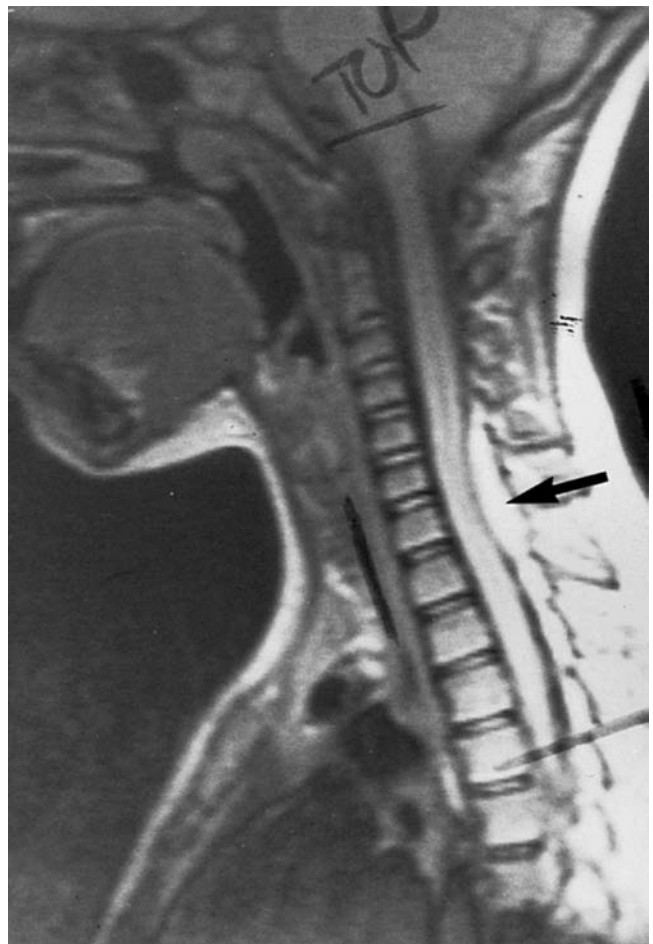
Magnetic resonance imaging (MRI) of cervical spine demonstrating epidural hematoma (arrow) from C5 to T1. Note excellent soft-tissue, intervertebral disc, and fluid detail afforded by the MRI scan.
